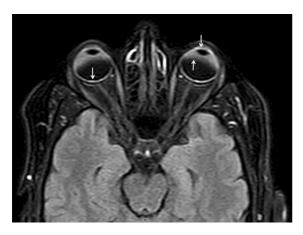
Axial 1.5 T post-contrast T2-FLAIR image shows bilateral susceptibility artifact (*arrows*) mimicking uveal tract enhancement in a healthy subject
